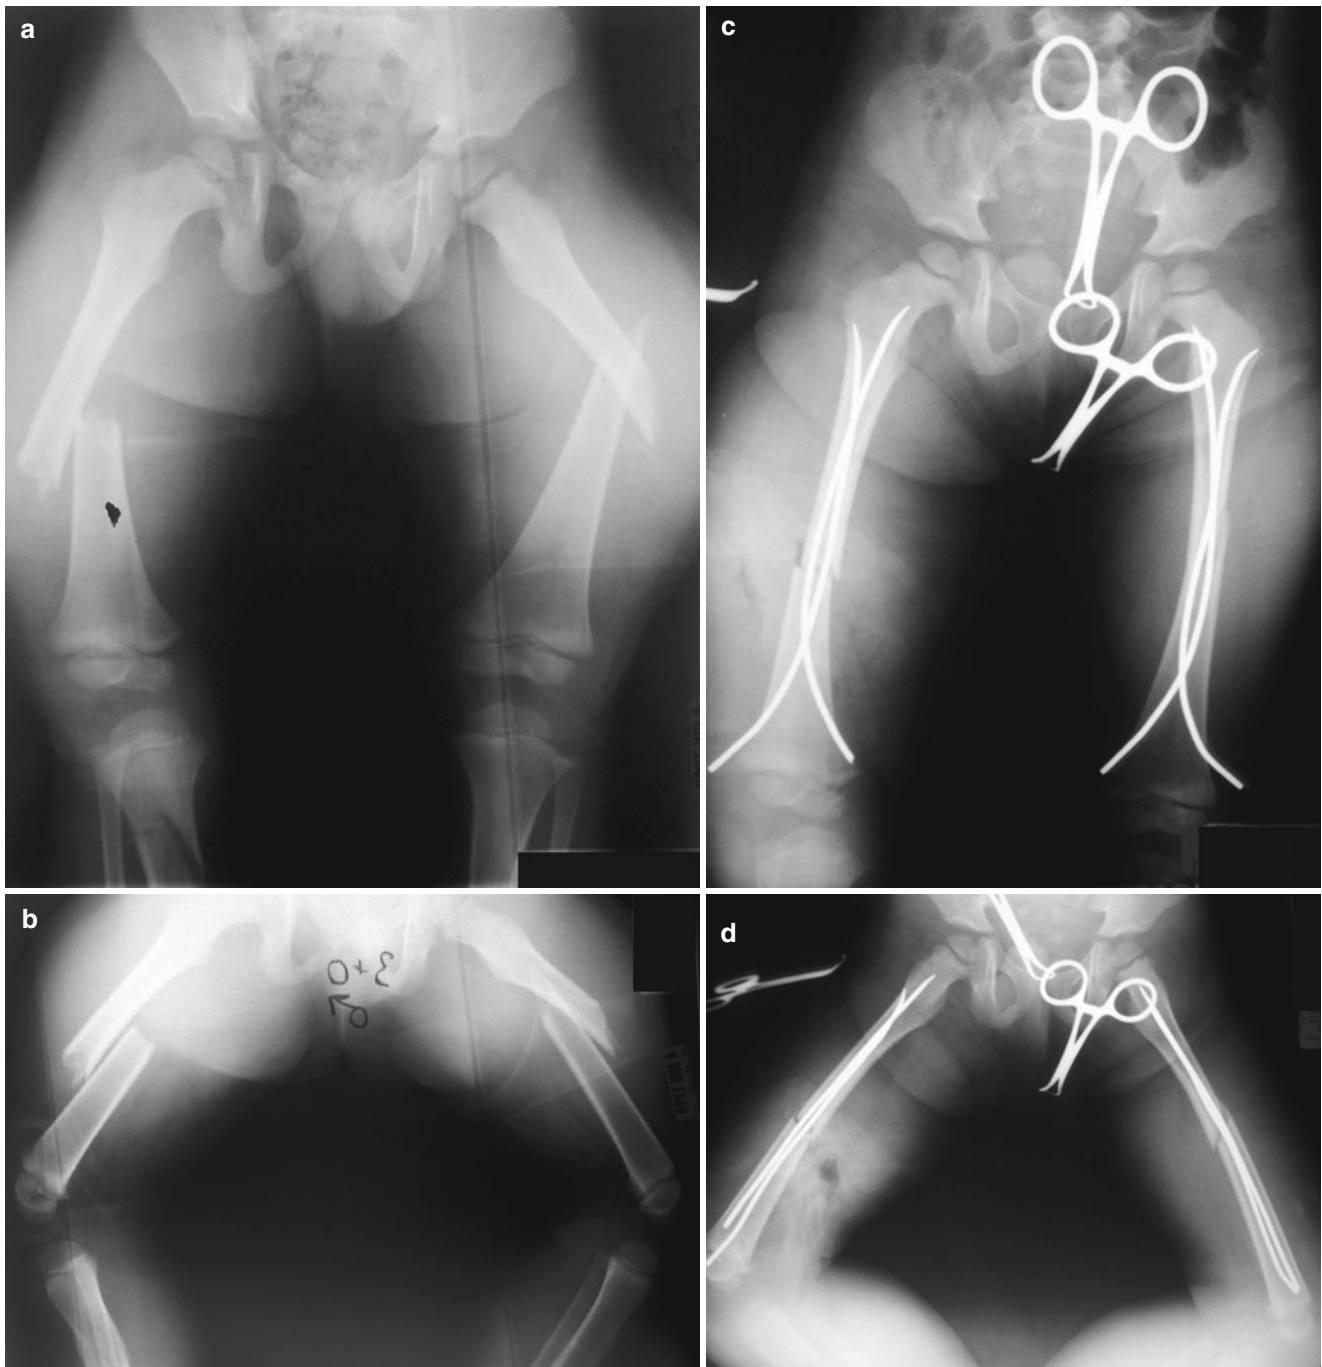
A 3-year-old male multiple trauma victim whose injuries included bilateral femoral shaft fractures. (a) Initial injury AP radiograph demonstrating transverse right and oblique left femoral shaft fractures. (b) Initial injury lateral radiograph of both femur fractures (the right one was also a Type I open fracture). (c) Post-operative AP
